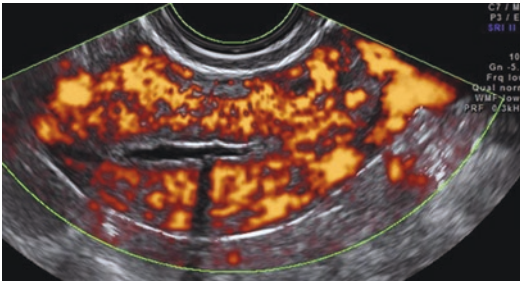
Power Doppler image of the uterus: prominent myometrial color signals but absence of detectable endometrial vessels (this is a normal finding in an atrophic or a postmenstrual endometrium)
